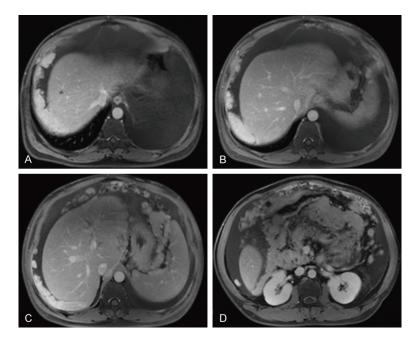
Enhanced MRI of the abdomen, showing the peritoneal and pleural effusions and heterogeneously enhancing nodules.
